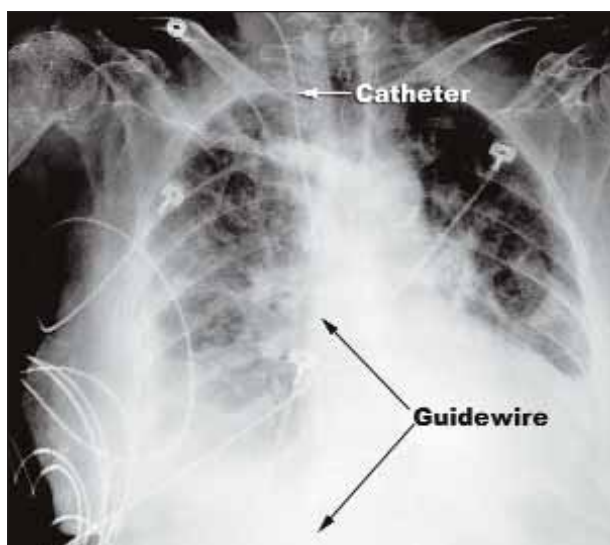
Immediate postprocedure portable chest radiograph showing the guidewire trapped within the catheter lumen, and the distal J tip is off the edge of the film.
